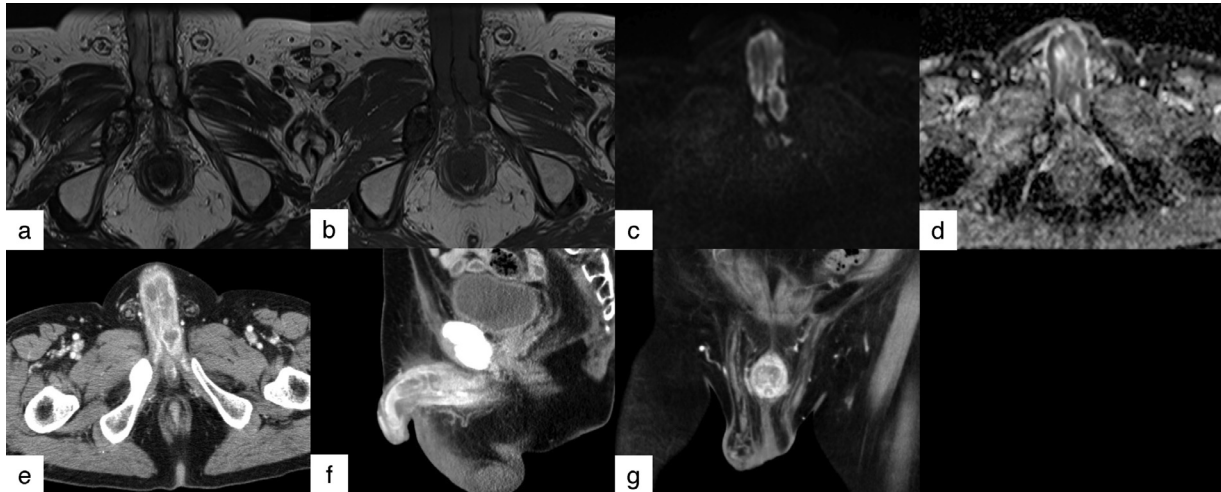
(A) Axial T2-weighted image; (B) Axial T1-weighted image; (C, D) Axial diffusion-weighted image ($b = 1000 \text{ s/mm}^2$) and apparent diffusion coefficient map; (E) Axial contrast-enhanced CT; (F) Sagittal contrast-enhanced CT; (G) Coronal contrast-enhanced CT. Follow-up MRI acquired 5 years after the initial MR images demonstrate a mass diffusely spreading to the bilateral penile corpus cavernosum. The contrast-enhanced CT axial (E) and sagittal (F) images show the tumor with predominantly marginal contrast enhancement. The contrast-enhanced CT coronal image (G) shows that the tumor extends across the septum of the penis. CT, computed tomography; MRI, magnetic resonance.
